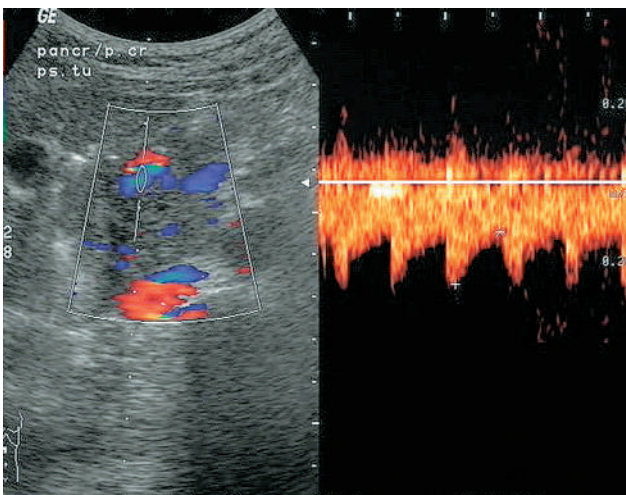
Pseudoaneurysm of the gastroduodenal artery (colour and spectral Doppler appearance).
